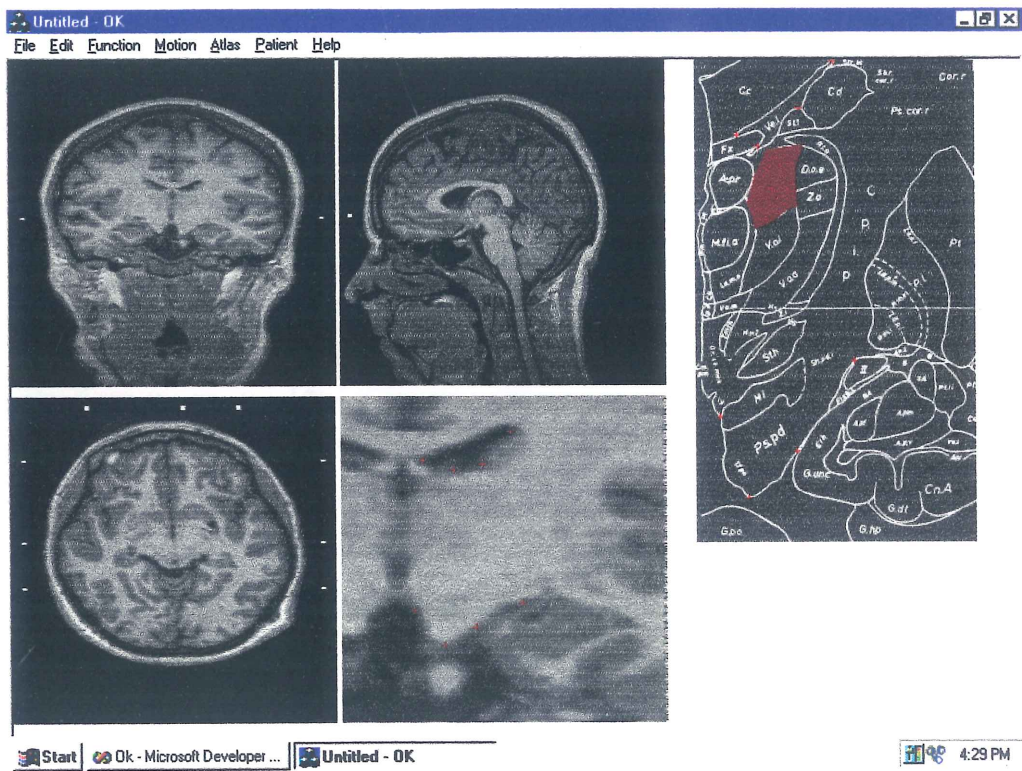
Deformation Points on CT and Atlas images with ROI.
